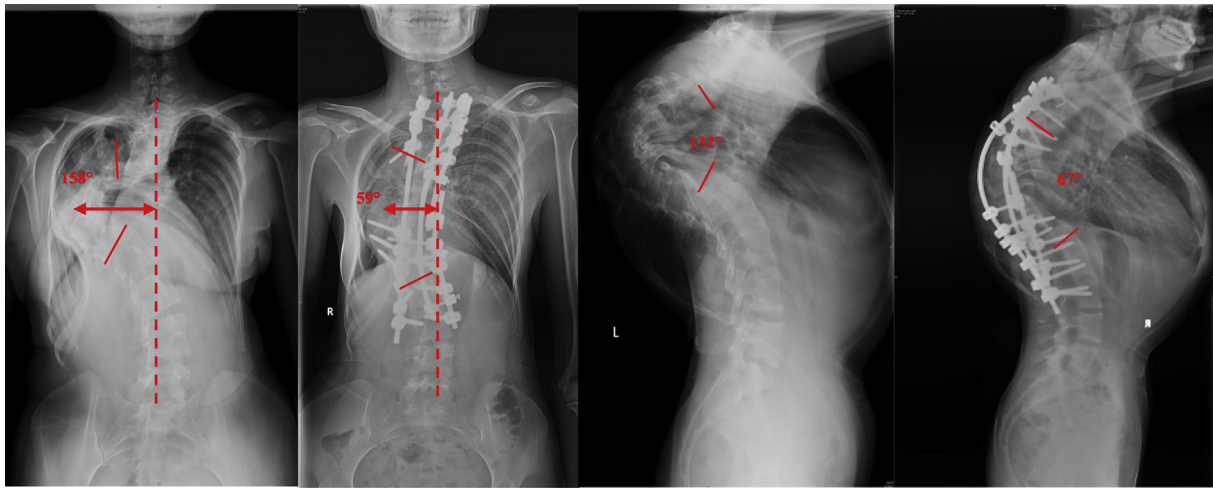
Full spine X-ray of a patient with kyphoscoliosis who underwent posterior pedicle instrumentations and corrected by Ponte osteotomy. The Cobb angle was measured between a line drawn parallel to the superior endplate of one vertebra and a line parallel to the inferior endplate of the vertebra. The preoperative Cobb angles are 158° and 132° in coronal and sagittal planes, respectively and the postoperative Cobb angles were 59° and 67°, respectively. The coronal and sagittal balance was achieved, and the AVT and the trunk height were improved. AVT, apical vertebrae translation.
